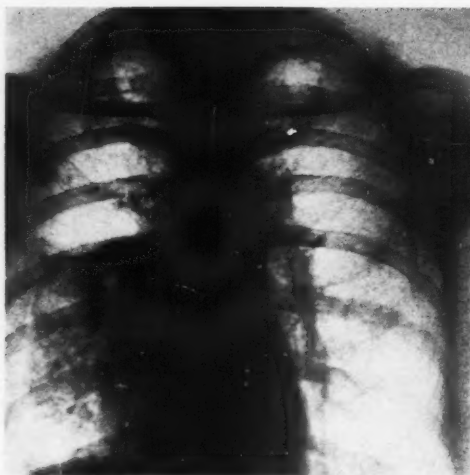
Physical signs essentially negative: bacilli Gaffky VII. Physical signs: right lung, breathing broncho-vesicular, vocal resonance increased, no râles. X-ray findings: moderately to far advanced.
